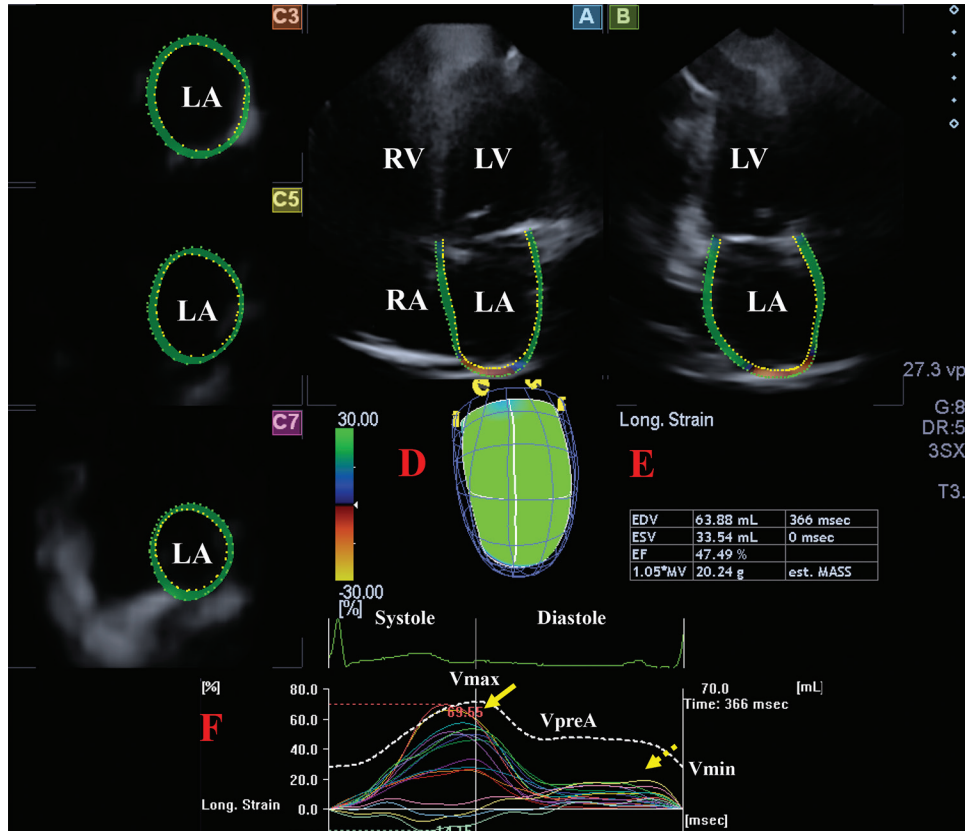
Three-dimensional speckle tracking echocardiographic left atrial (LA) analysis using a full-volume dataset in a healthy subject is demonstrated: (A) Apical four-chamber and (B) two-chamber views, short-axis views (C3) at basal, (C5) midatrial and (C7) superior LA levels are demonstrated with (D) a three-dimensional LA cast. (F) Time – global LA volume change (dashed line) and time – segmental LA longitudinal strain curves (coloured lines) with (E) calculated volumetric LA data are presented. Yellow arrow represents peak LA strains, while yellow dotted arrow represents LA strains at atrial contraction. LA= Left atrium, LV = Left ventricle, RA = Right atrium, RV = Right ventricle, EDV = End-diastolic volume, ESV = End-systolic volume, EF = Ejection fraction, V_{\max} = Maximum LA volume, V_{preA} = Preatrial contraction LA volume, V_{\min} = Minimum LA volume
